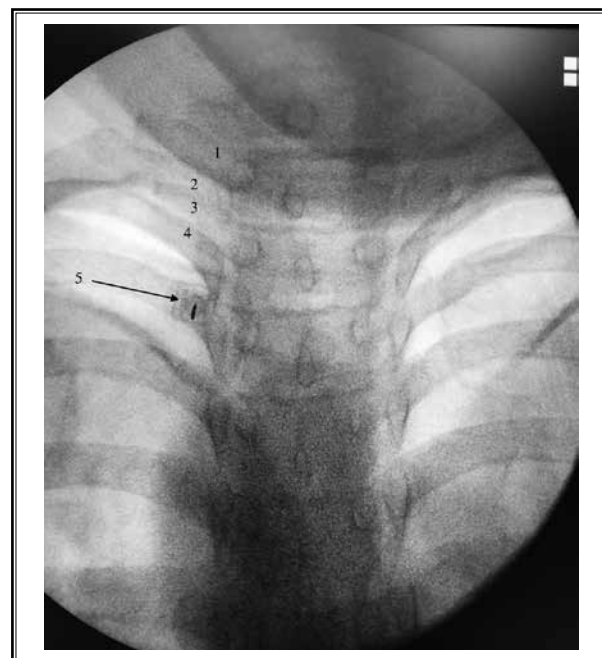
An A-P x-ray view of the upper thoracic spine depicting the thoracic PVN procedure. 1 = the transverse process of the first thoracic spine (slanting upward and ballooned). 2 = the first rib. 3 = the transverse process of the second thoracic vertebra. 4 = the second rib. 5 = the arrow points to the RF needle (end on view) landing on the lower border of the transverse process of the third thoracic vertebra.
